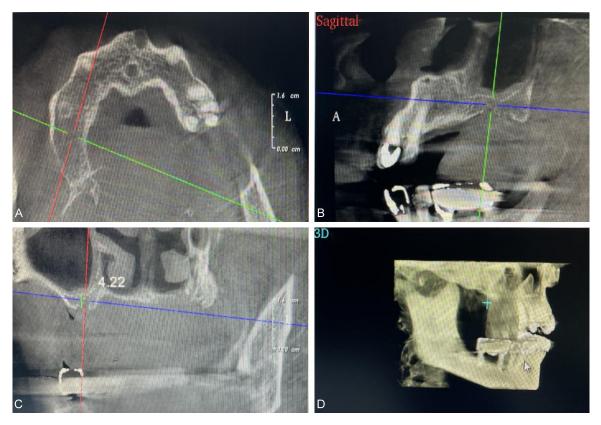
Postoperative CBCT. A: Axial view showing the dental arch with implant in place; B: Sagittal view displaying the maxillary sinus and implant position; C: Coronal view indicating the implant and surrounding bone structure; D: 3D reconstruction of the maxillofacial region post-implantation. Note: CBCT, Cone-Beam Computed Tomography.
